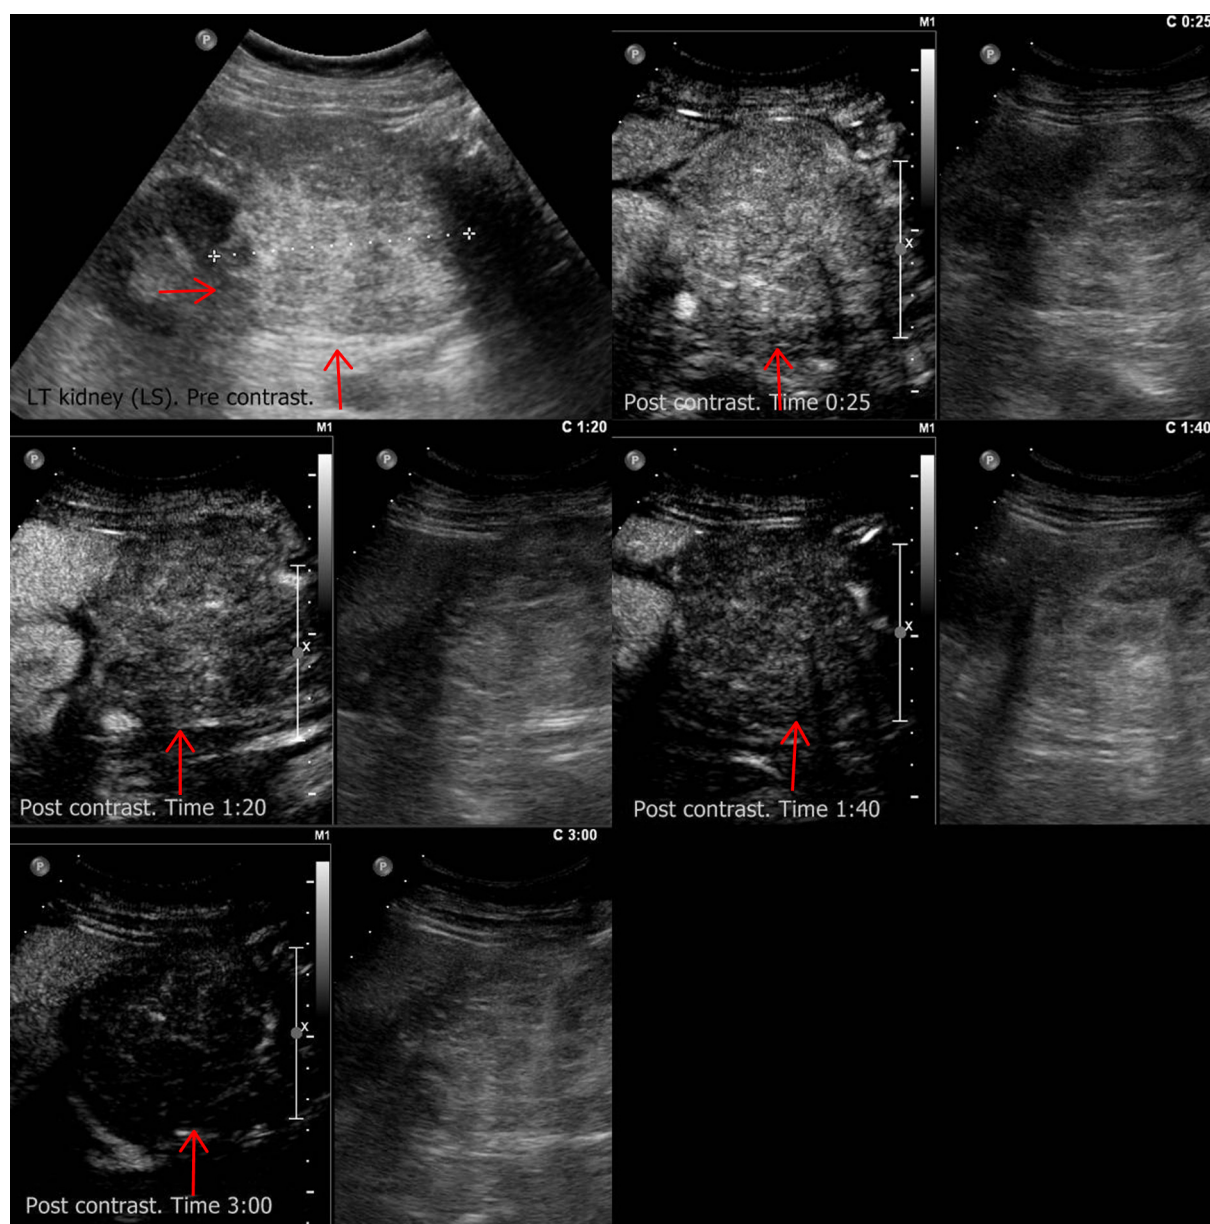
Renal angiomyolipoma in an 8-year-old boy, with incidental note of a left kidney mass on bedside ultrasound. Noncontrast images show a large echogenic exophytic mass, which shows postcontrast enhancement, which is less enhanced than the normal renal parenchyma on all phases. No significant washout is seen within the lesion.
